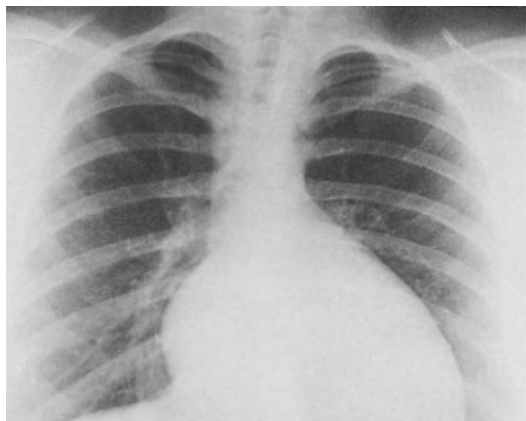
The chest X-ray in Ebstein disease. The cardiac silhouette resembles that of a pericardial effusion.
